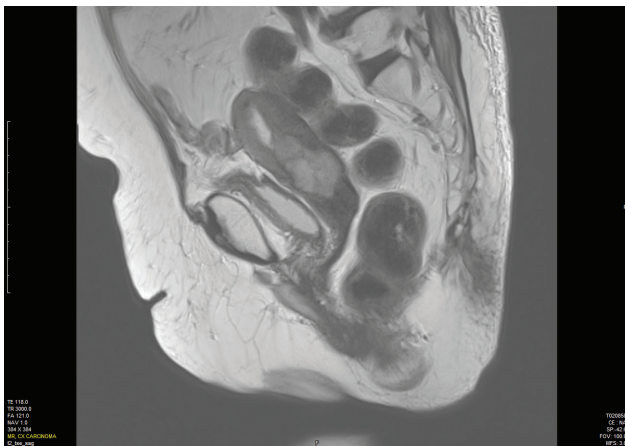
Sagittal T2-weighted magnetic resonance image showing a mass over 7 cm in size in the uterine cervix with hematometra.
